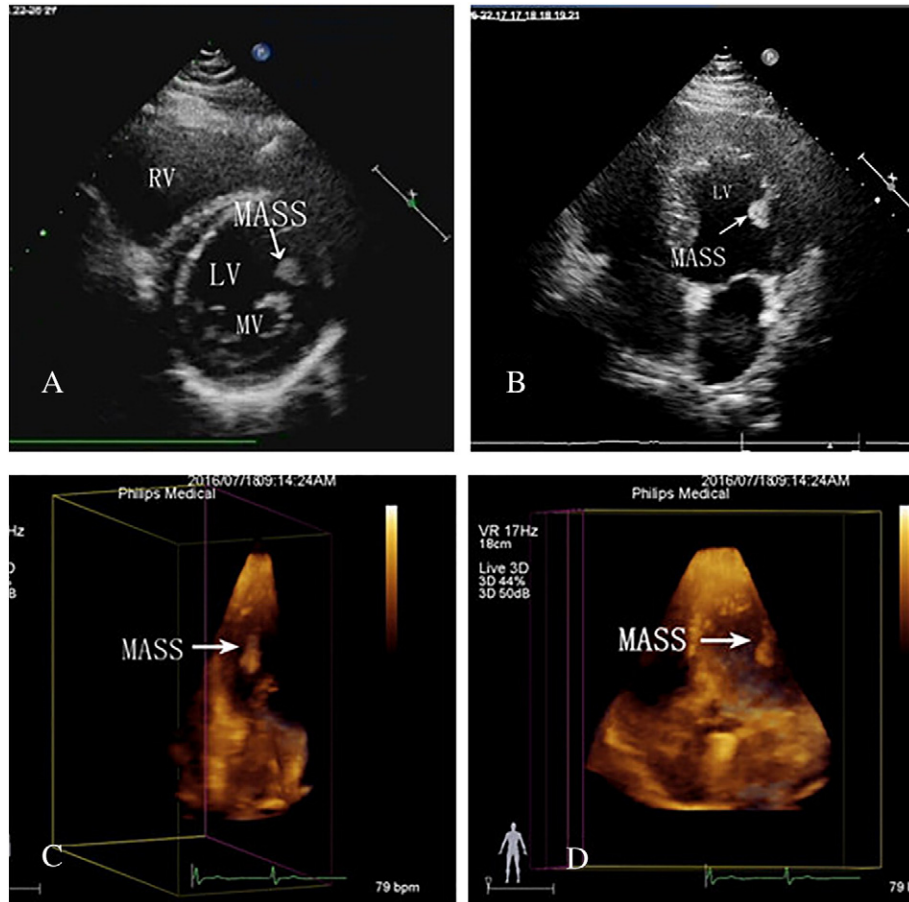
A, B: Transthoracic two-dimensional echocardiography showed the mass in the left ventricle; C, D: Transthoracic three-dimensional echocardiography showed the tumor connected to the lateral wall of left ventricular. LV: left ventricular RV: right ventricular MV: mitral valve.
